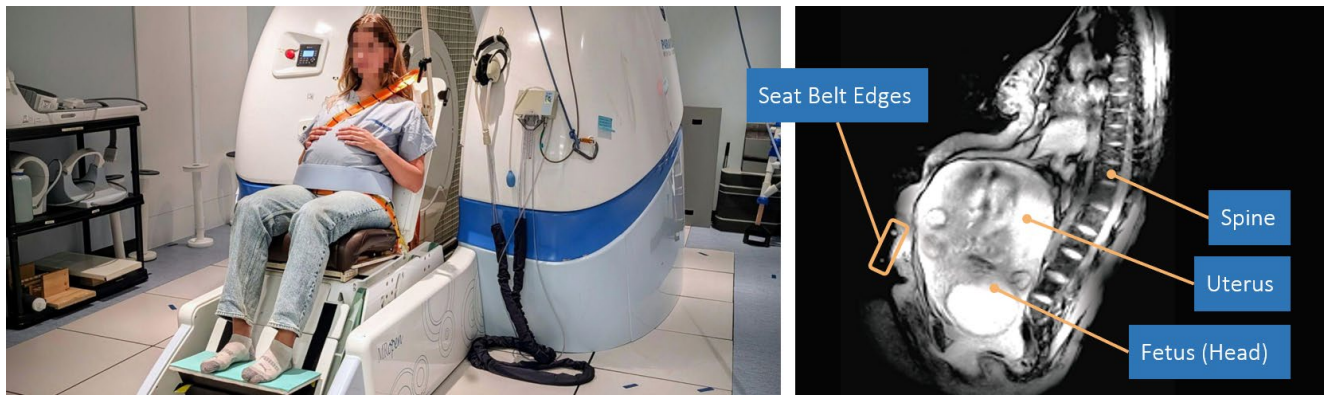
Left*: a volunteer inside the Open MRI, positioned on the automotive seat replica. *Right*: a sagittal MRI slice of a pregnant volunteer, capturing the seat belt, fetus, uterus, and maternal spine.
